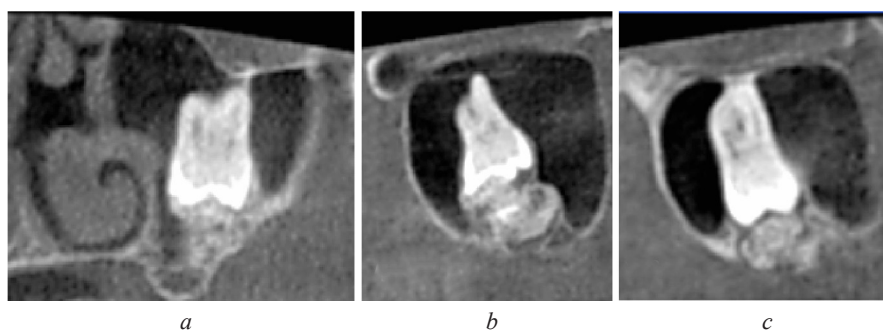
CBCT, coronal (a), and sagittal (b, c) images showing complex odontoma associated with impacted inverted tooth 2.6
